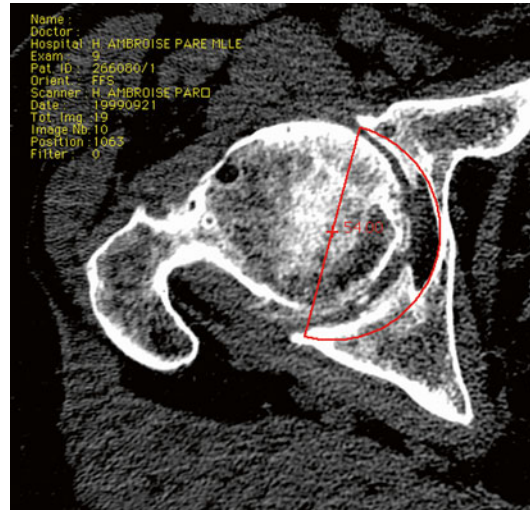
Planning of the acetabular socket using CT image
